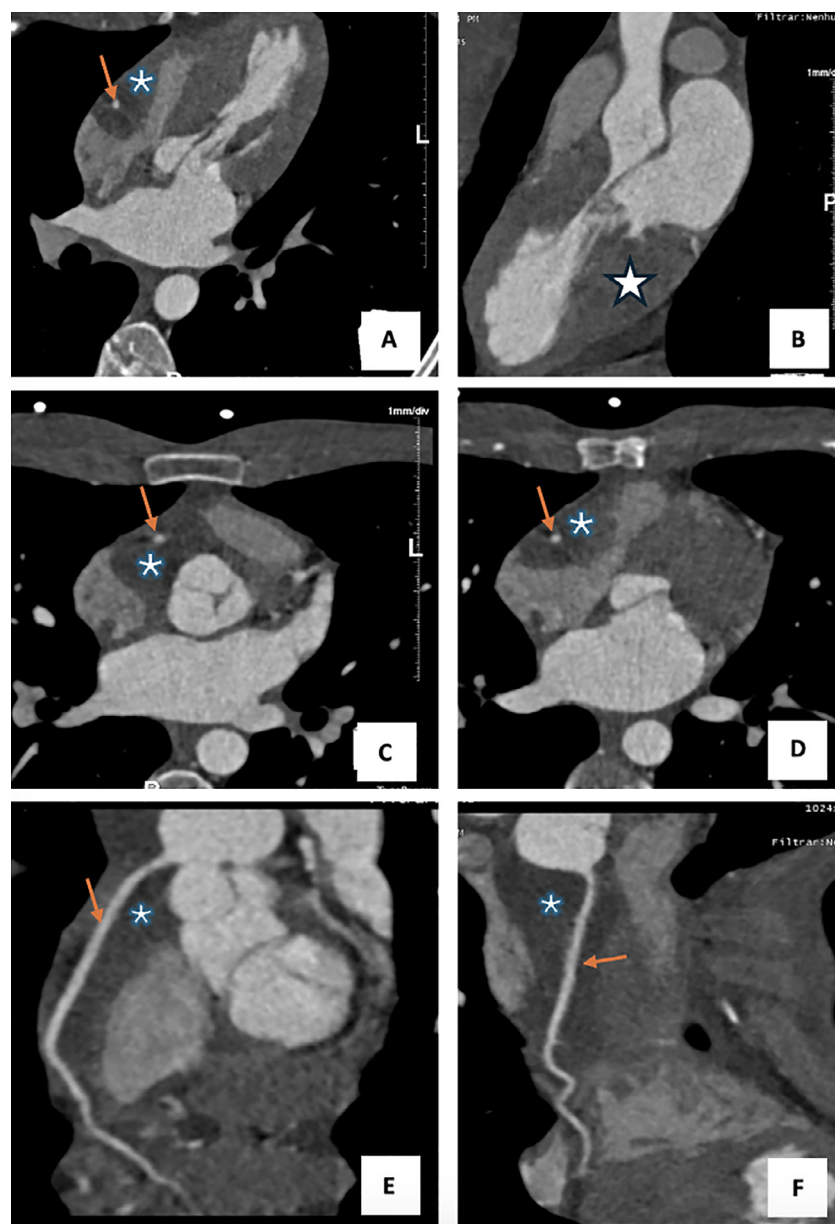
Multiplanar reconstructed coronary CT showing a mass (*) and systolic anterior motion of the mitral valve (A and B); intrapericardial lesion (*) with molding effect on the right atrium (C and D), surrounding the RCA (→) (E and F). LV hypertrophy (star).
